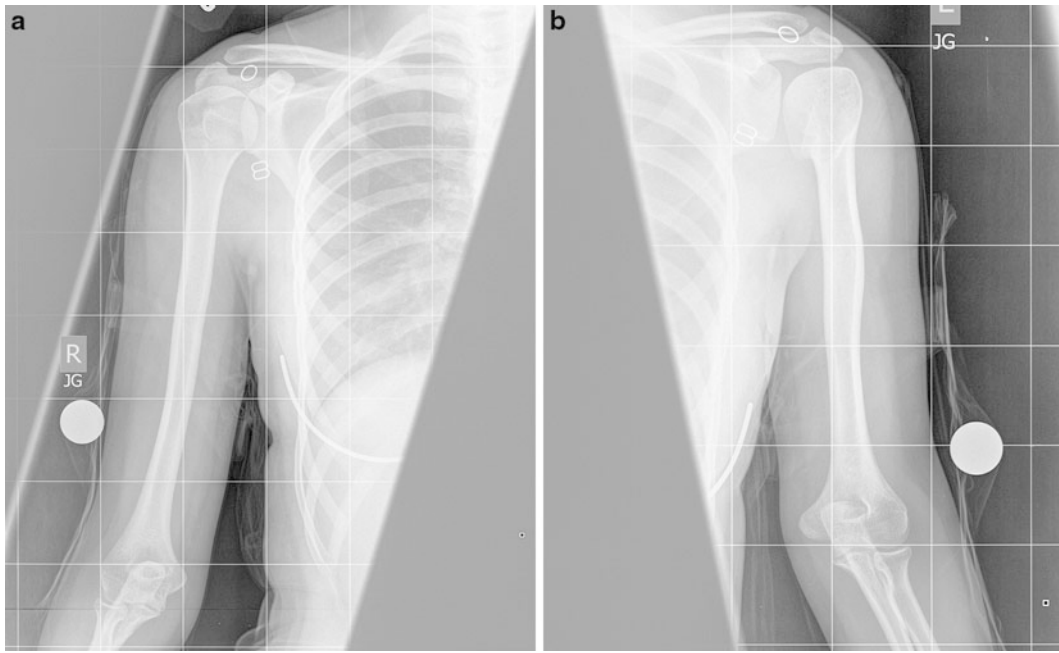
(a, b) AP X-ray of the right and left humerus, showing left-sided shortening
